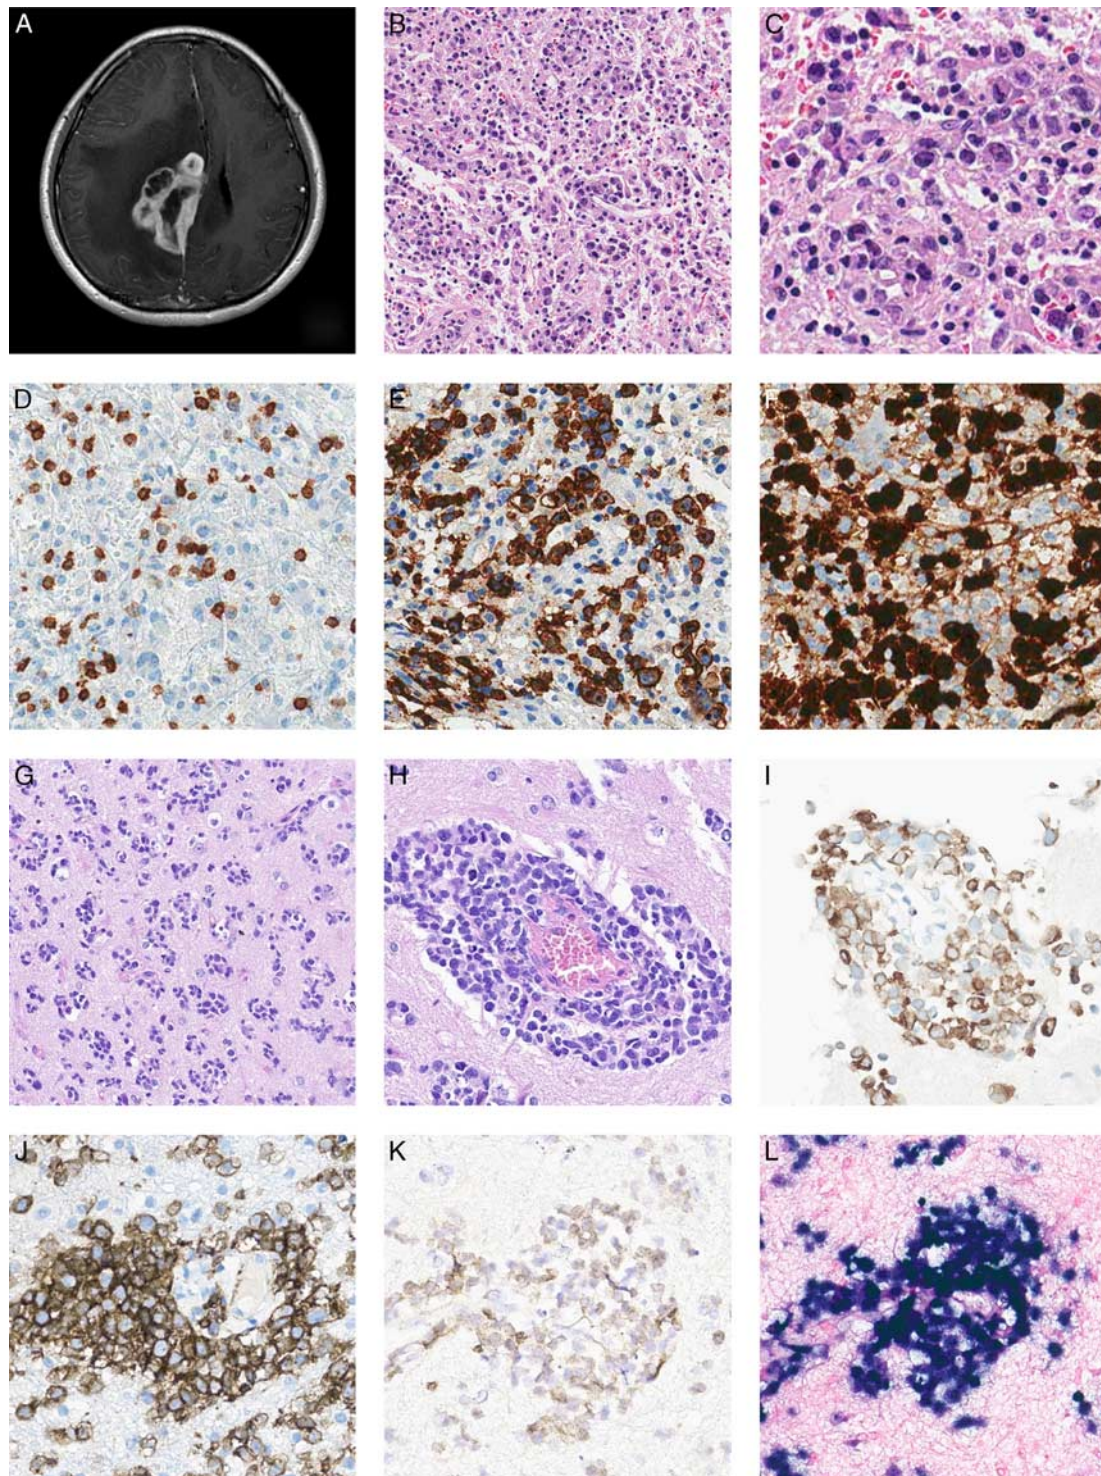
Representative images of case 4 (anaplastic lymphoma kinase-positive anaplastic large cell lymphoma) (A–F) and case 11 (extranodal natural killer/T-cell lymphoma of $\alpha\beta$ T-cell lineage) (G–L). A, Brain magnetic resonance imaging of case 4 showed a solid and cystic mass involving the right cingulate, corpus callosum body and parieto-occipital region. Large pleomorphic anaplastic cells were infiltrating brain parenchyme (B, C). Most of the anaplastic cells were negative for CD3 (D), but positive for CD30 with a strong membranous and Golgi pattern (E), and for anaplastic lymphoma kinase with strong cytoplasmic and nuclear pattern (F). In case 11 (extranodal natural killer/T-cell lymphoma of $\alpha\beta$ T-cell lineage), large atypical lymphoid cells were infiltrating brain parenchyme along small vasculature or in a perineuronal satellitosis pattern (G). Clear perivascular cuffing of atypical cells was observed (H). Tumor cells were diffusely positive for CD3 (I), CD8 (J), TCR β F1 (K), and Epstein-Barr virus (L).
